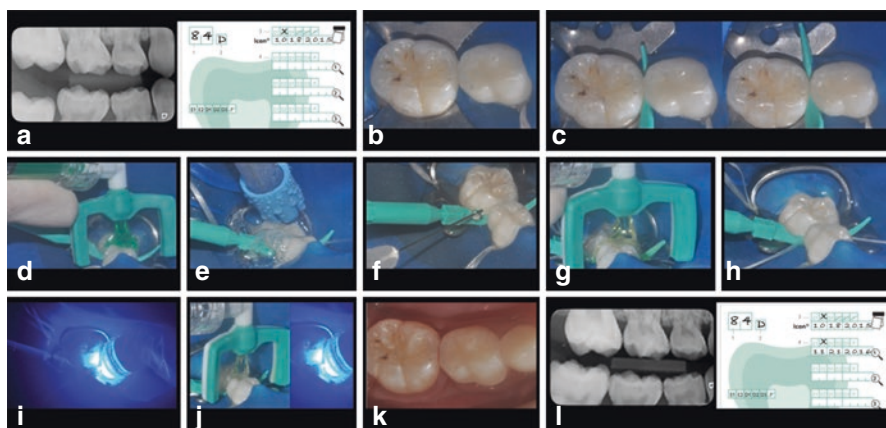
Clinical case showing the initial diagnosis of a proximal lesion scored as E2 in tooth 84 (a); caries infiltration procedure step by step: rubber dam (b); insertion of the wedge for tooth separation (c); etching with 15% HCl gel for 2 min (d); rinsing (e) followed by air-drying; ethanol application for 30 s (f) followed by air-drying; application of the infiltrant for 3 min (g); excess removal with dental floss (h); light curing for 40 s (i); reapplication of the infiltrant for 1 min followed by light curing for 40 s (j); clinical aspect right after removing the rubber dam (k); and the follow-up radiograph and the identification card after 1 year (l)
